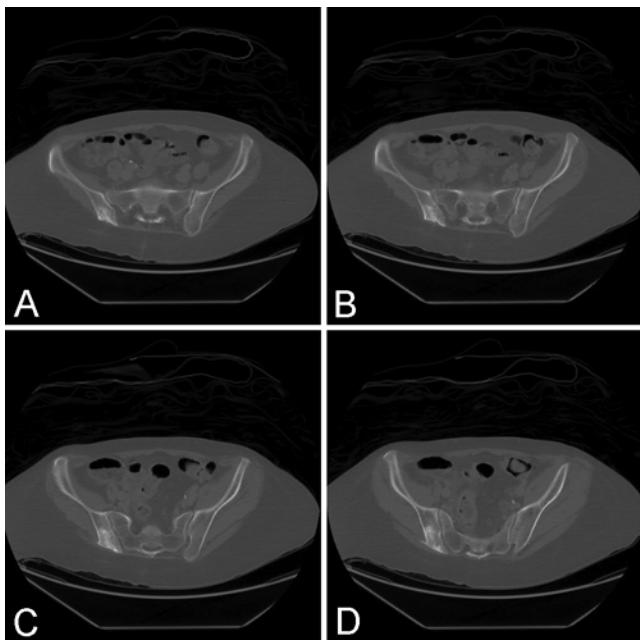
Intraoperative axial images obtained with cone beam CT. Sequential images reveal the iliac crest defect on the patient's left side, which was reconstructed with cortico-cancellous allograft. Note the allograft extending beyond the confines of the native iliac crest margins.
